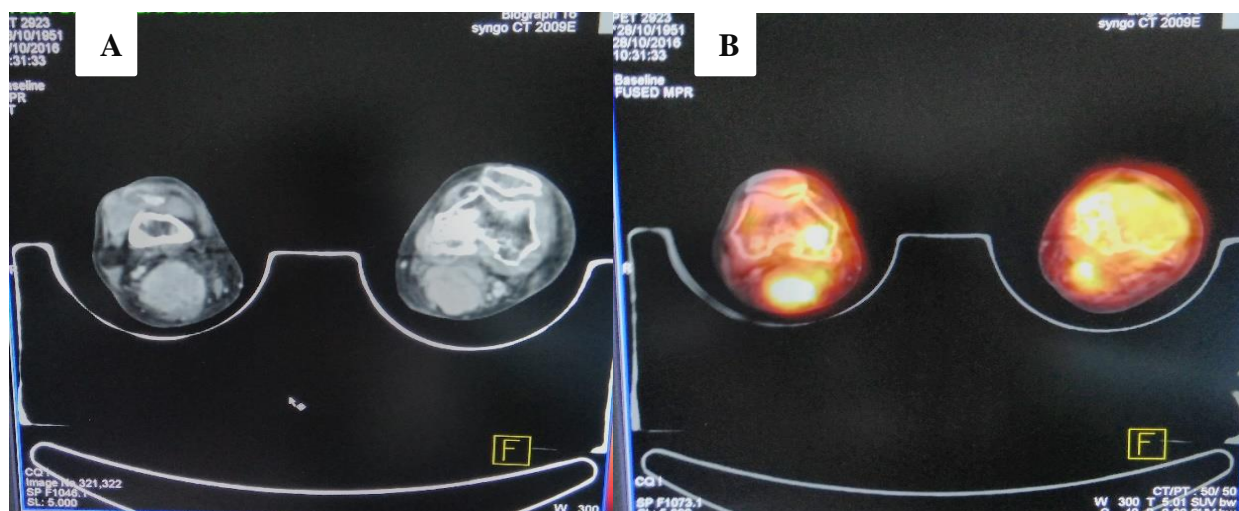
(A) CT Scan- Ill-defined lytic lesion was observed involving upper tibia and tibial plateau and lower femoral condyles. (B) PET-CT scan- maximum size of lesion measuring 11.7cm x 8.1cm x 7.4cm showing few non-enhancing necrotic foci.
